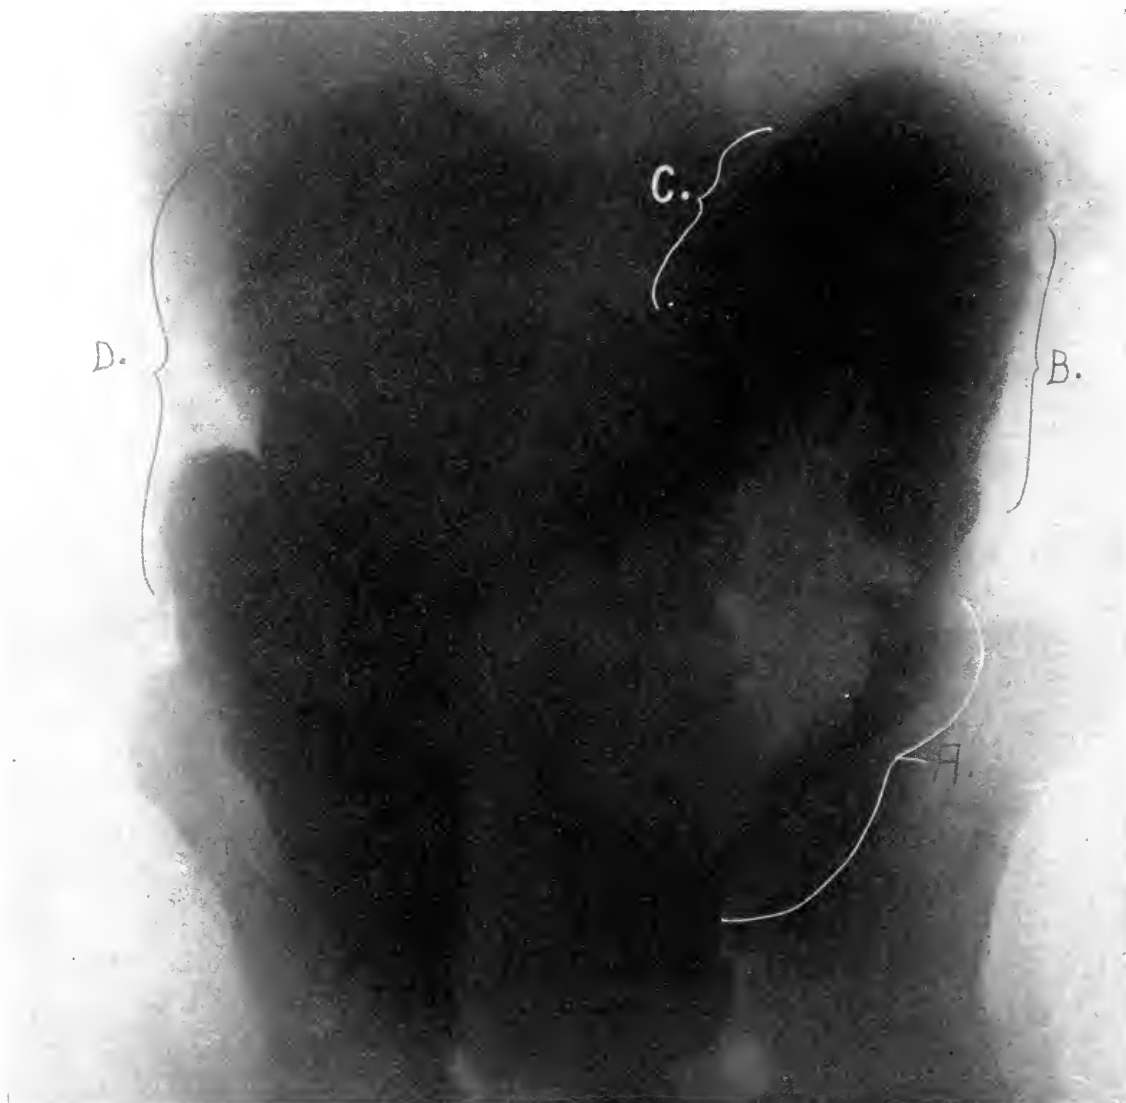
Case 1. Roentgenogram showing the colon after approximately sixteen weeks of specific treatment. At A there is disappearance of local strictures, loss of the ragged, ulcerated bowel contour, with replacement by smooth mucous membrane surface; at B appearance of peristaltic waves in section of gut, proximal to previous stenosis; at C entire disappearance of stenosing gumma; at D peristalsis appearing in the zone of previous dilatation. (Joseph Johnson, roentgenographer).
